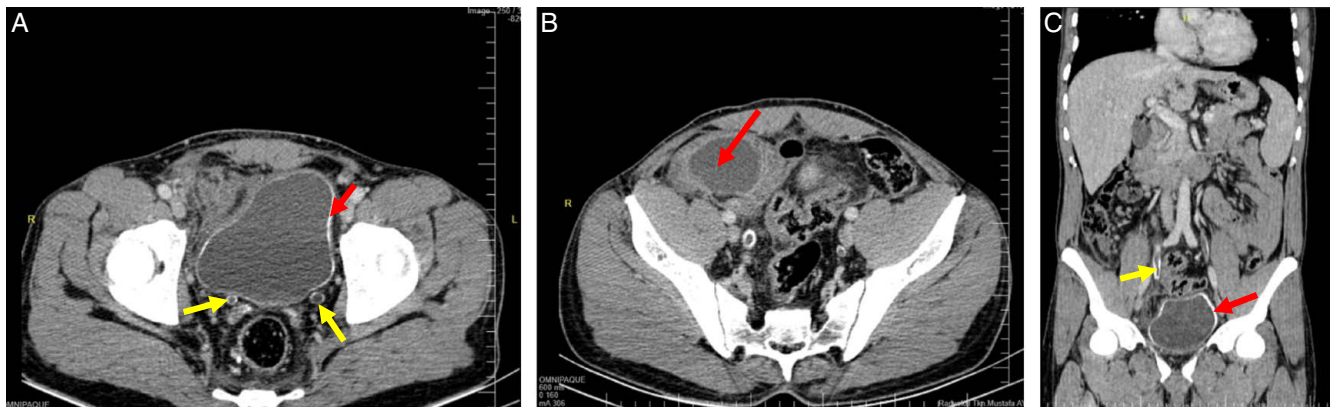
Axial contrast-enhanced abdominopelvic computed tomography shows (A) Extensive calcification of the urinary bladder (red arrow) and both ureter walls (yellow arrow). (B) An abscess cavity containing hypodense fluid posterior to the terminal ileum (red arrow); fat stranding surrounds this collection, and the appendix is not clearly identified. (C) Coronal contrast-enhanced abdominopelvic computed tomography shows extensive calcification of the urinary bladder (red arrow) and both ureter walls (yellow arrow).
